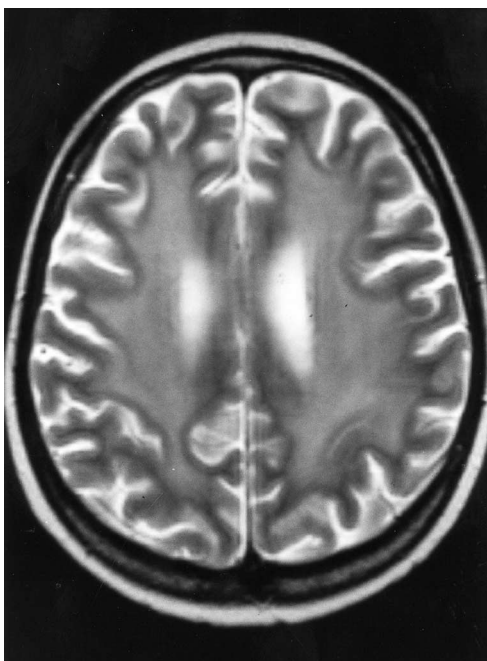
Axial T2-weighted magnetic resonance imaging brain scan showing diffuse subcortical white matter signal change in a young woman presenting with dementia, rigidity and incontinence 3 months after a bone marrow transplant for Philadelphia positive acute lymphoblastic leukaemia in second complete remission. The patient had previously received a combination of intrathecal methotrexate and brain radiotherapy as part of her conditioning protocol. The diagnosis was of a methotrexate-induced leucoencephalopathy. She died within 3 weeks of the scan.
